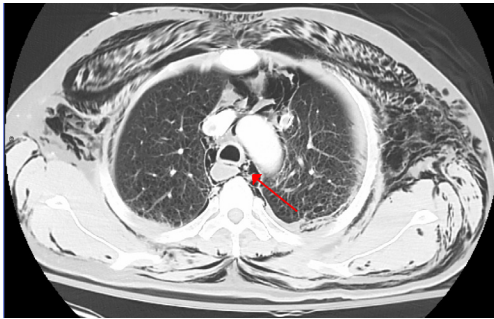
Pneumomediastinum on chest CT as demonstrated by red arrow. This figure is licensed under the Creative Commons Attribution-Share Alike 3.0 Unported License. Initial image is created by James Heilman, MD and is under the public domain because it is a work of medical imaging created in the United States and does not contain additional copyrightable graphics. Informed consent was obtained prior to uploading the image by the initial author. CT, computed tomography.
